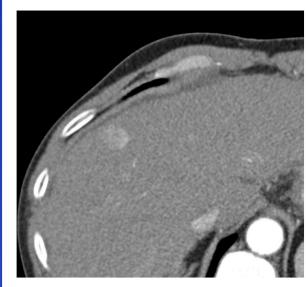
Pre-transarterial radioembolization (TARE) treatment contrast-enhanced CT showing arterial phase enhancement of hepatocellular carcinoma (HCC) lesion in segment 8 of the liver. This lesion also demonstrated portal venous phase washout that is not pictured.
